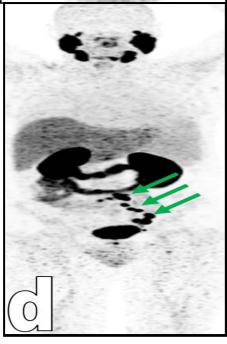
65 year old patient with history of prostate neoplasm underwent prostatectomy, now elevated PSA level 5.16 ng/ml. Lymph node: a) Axial CT, (b) fused PET/CT and (c) axial PET PSMA avid pathologically enlarged aortocaval, left para-aortic left common and internal iliac nodes, the most active is the left internal iliac having SUVmax 45.8 and measures 1.8 cm (Red arrows). (d) Maximum intensity projection image (MIP) shows PSMA avid pathologically enlarged aortocaval, left para-aortic left common and internal iliac nodes.
